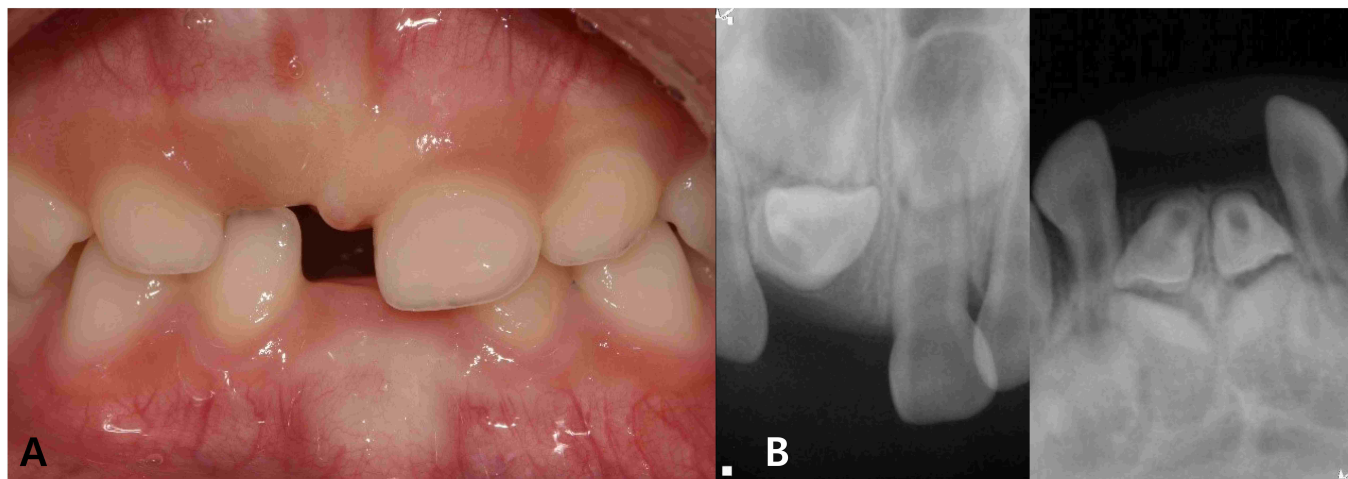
Condition of the primary incisors at the initial visit. (A) Intraoral photo at the initial visit, with no eruption of teeth #51, #71, and #81. (B) Periapical radiograph of teeth #51, #71, and #81.
